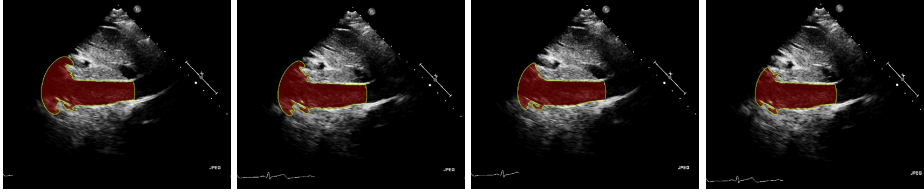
Tracking result of coronary artery from echocardiographic sequences in a cardiac cycle
